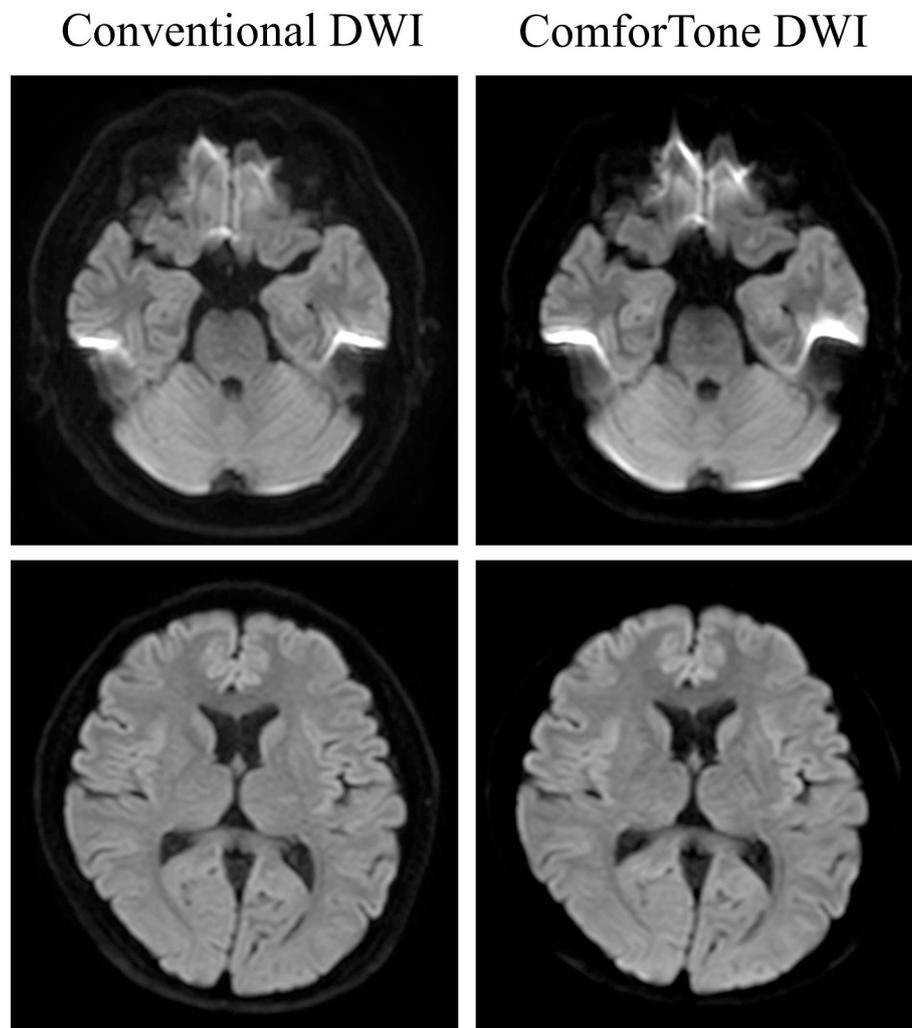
Representative slices of the conventional DWI sequence (left column) and the ComforTone sequence (right column) of a healthy volunteer reveals that the susceptibility artifact is increased in the ComforTone DWI.
